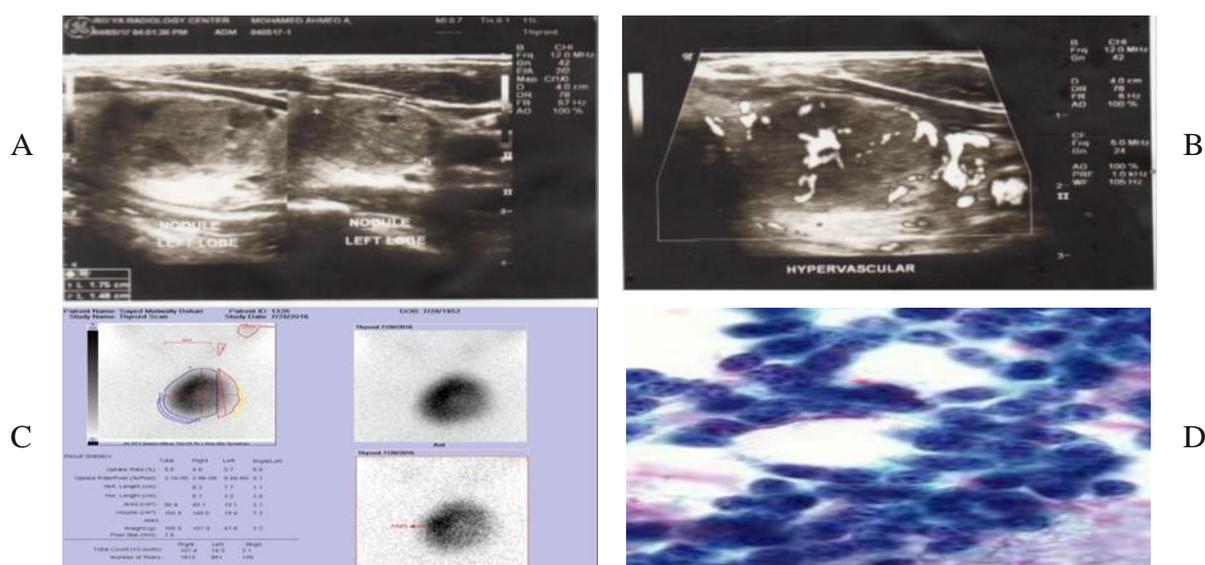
Forty three years old male, A; US image displayed well defined slightly echogenic solid left lobe nodule with areas of breaking down, B; Doppler image showed central and peripheral vascularity. C; thyroid scan image portrayed left lobe adenoma with heterogeneous uptake, suppression to the other lobe and uptake = 6.5%. D; FNAB revealed papillary thyroid carcinoma, with cellular aggregates of follicular cells with intra-nuclear inclusions and many nuclear inclusions , some of them are optically clear nuclei .
